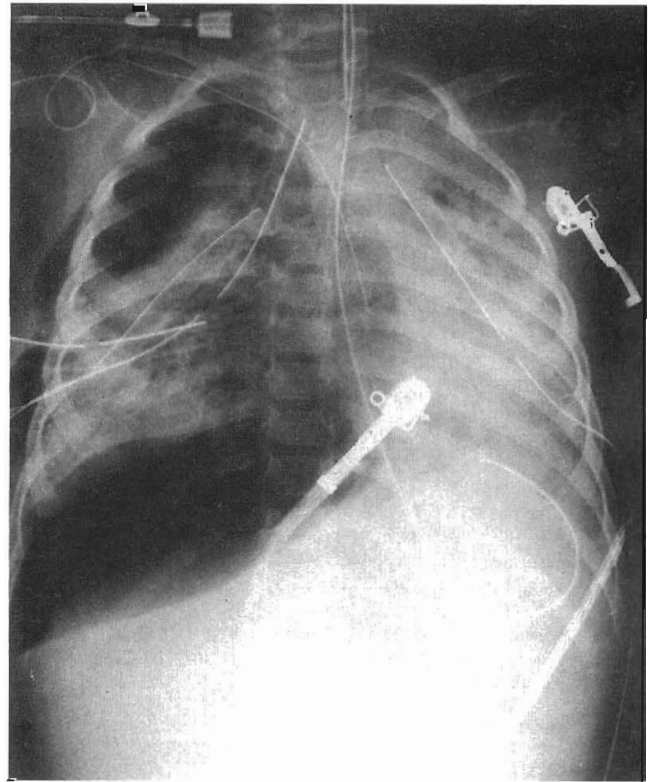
Portable anteroposterior chest radiograph from a patient with late fibroproliferative acute respiratory distress syndrome and large right sided tension pneumothorax. The patient had multiple episodes of tension pneumothorax due to pulmonary barotrauma and required multiple bilateral tube thoracostomies.
